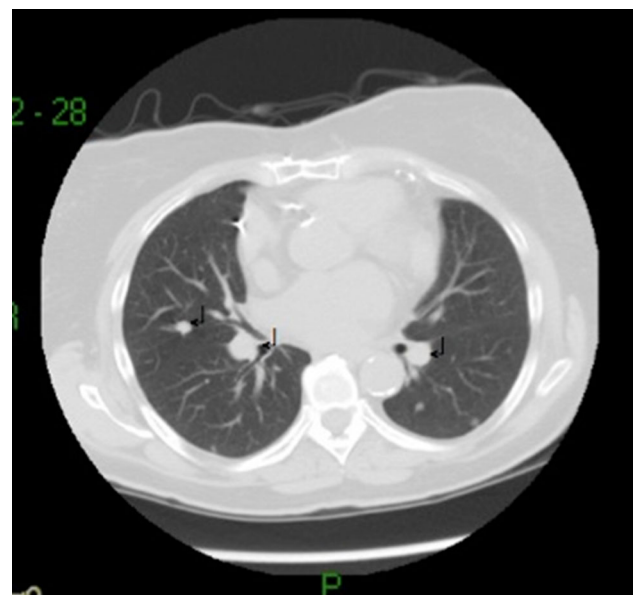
Chest CT from a patient with DIPNECH who presented with multiple pulmonary nodules
